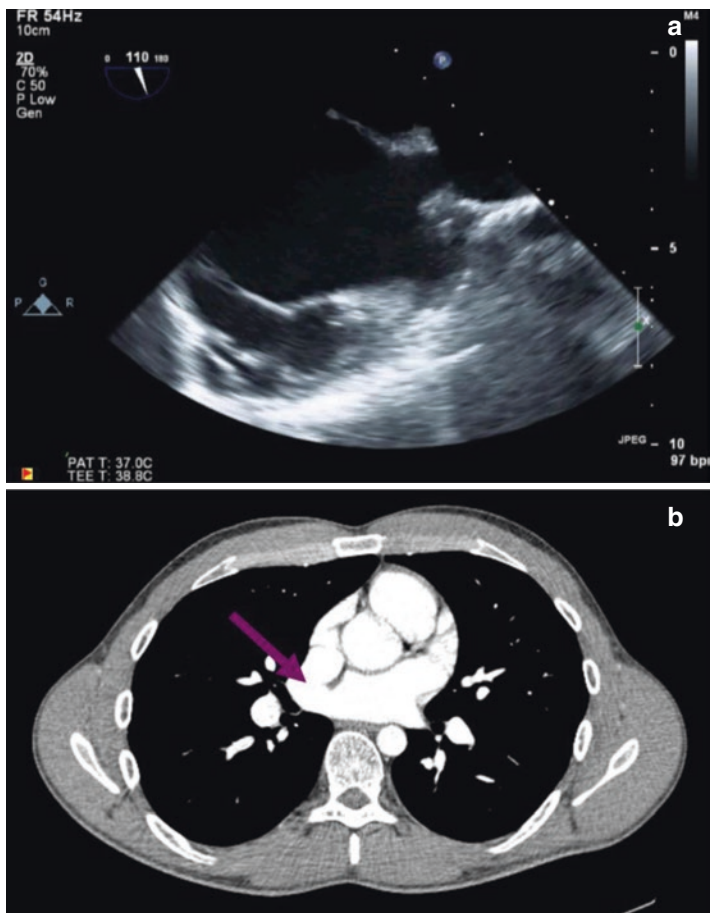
(a) Transesophageal echocardiography of a superior sinus venus defect. The SVC is to the right of the image. (b) Cardiac CT angiogram axial image depicting a superior sinus venus defect
